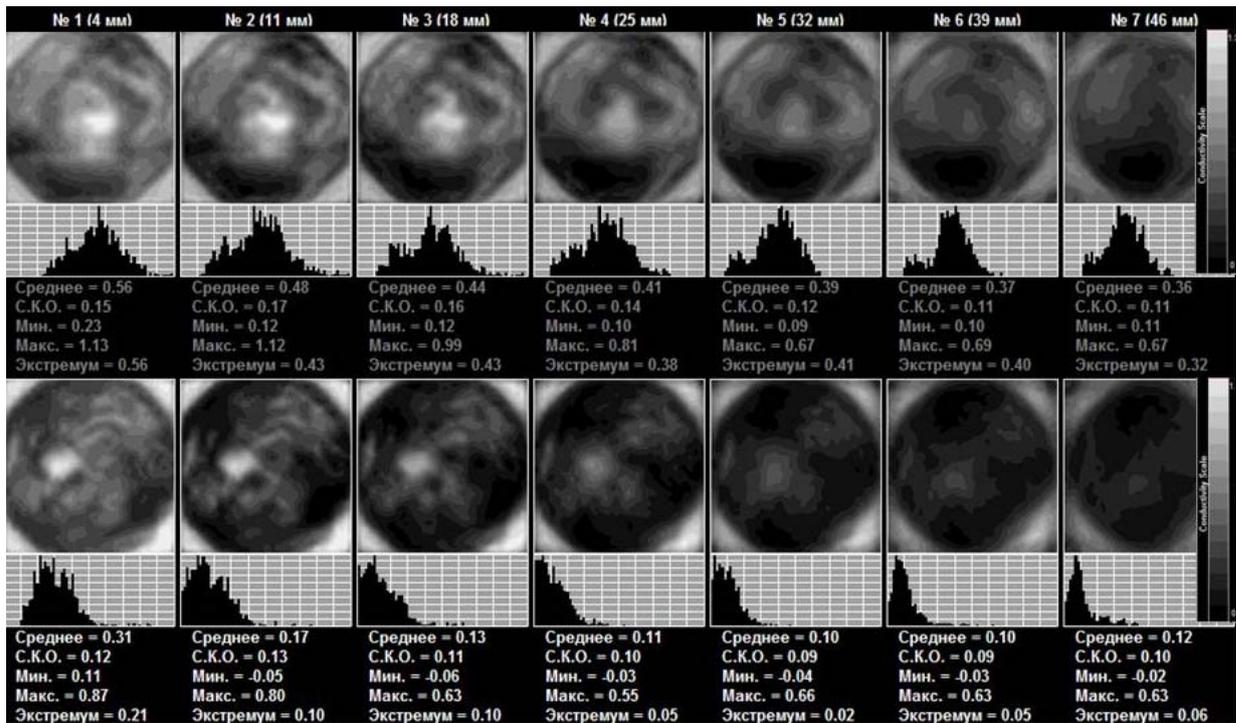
EIM. Top row – left gland. Mixed type of mammary gland structure. Lower row – right gland. Well-defined hyper-impedance background. The anatomy is altered. Electrical conductivity index is three-fold less than normal. ULTRASOUND: Diffuse Type of Cancer
